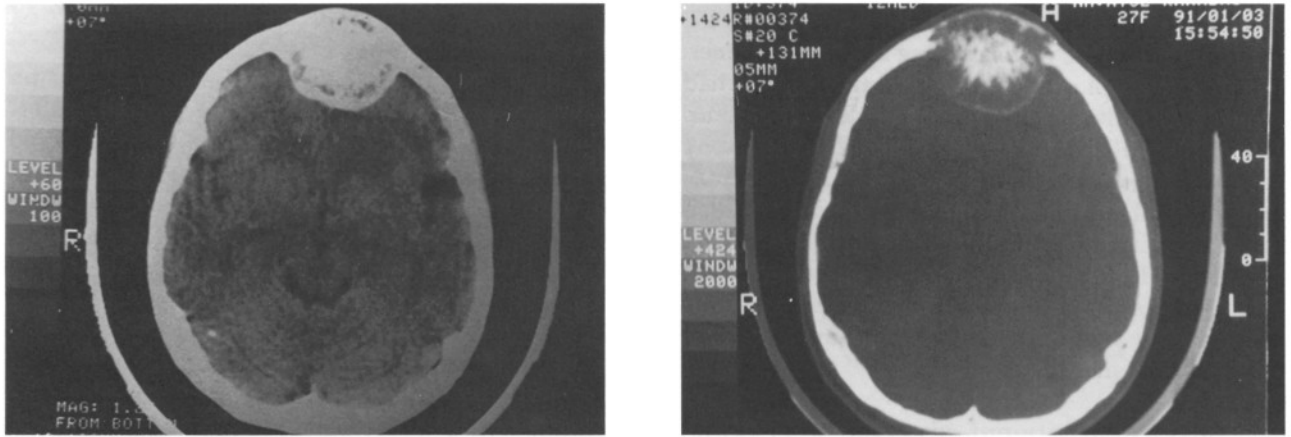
A CT scan shows an expanding hyperdense mass with radiating hyperdense areas located in the frontal bone of the cranium.
